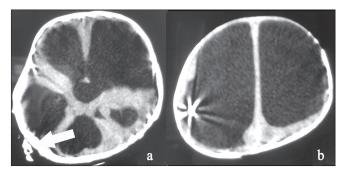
CT scan showing subgaleal coiling of the shunt tube
